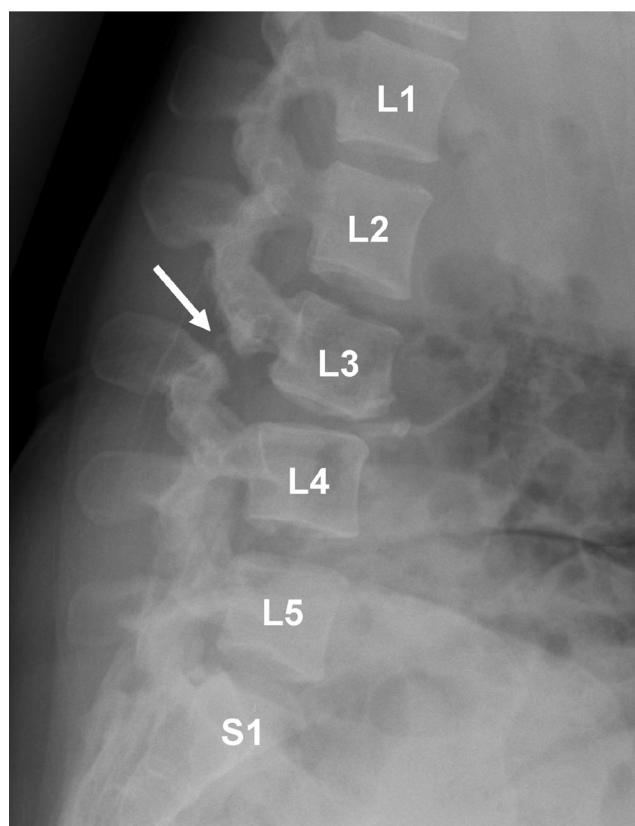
Evident underlying pathology for low back pain symptoms on initial radiographs. A lateral flexion radiograph showing bilateral pars defects at L3 (arrow) with abnormal motion at L3–L4. No further workup was deemed necessary to look for alternative diagnosis to explain the patient's pain symptoms.
